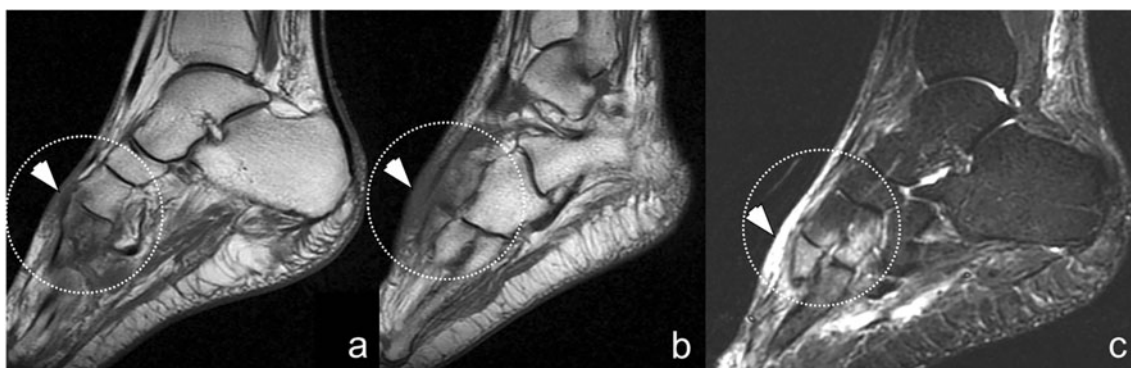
Bone marrow edema in a 60-year-old diabetic woman with neuropathic osteoarthropathy. a, b Sagittal T1-weighted, and c short-tau inversion recovery (STIR) MR images show that the marrow in the tarsometatarsal region has a low signal intensity on the T1-weighted
